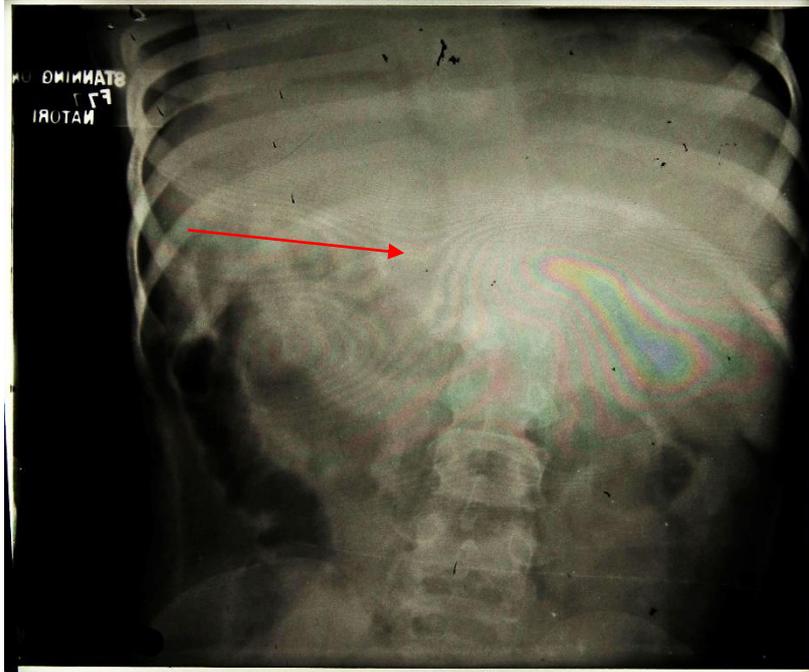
Patient 87/62 Radiograph report 2nd May 1938: 'Angle at site of deformity much increased. More collapse. Disease extending down and decalcification very marked'. The swirled pattern in this image, a result of the digitisation process, obscures part of the lesion under observation (arrow) adding to the difficulty of reading an AP image. Although pathology is unobservable lateral displacement is clear (HOSP/STAN/7/1/2/487_13)
